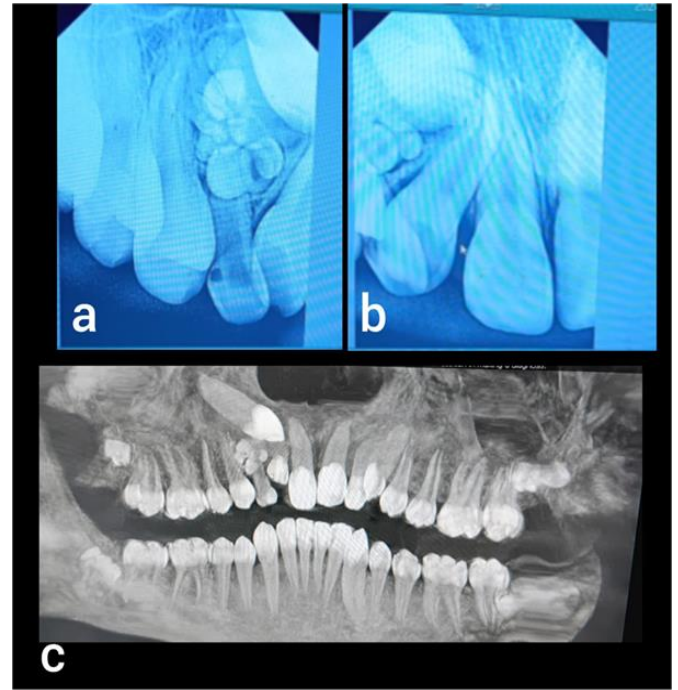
CBCT imaging of compound Odontoma
